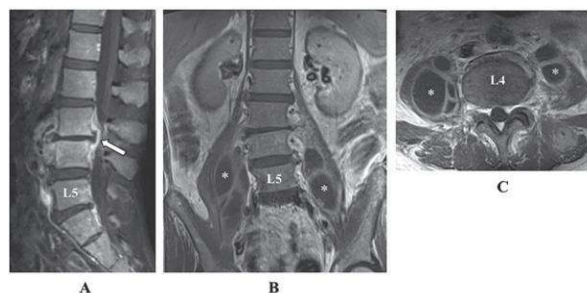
Magnetic resonance imaging (MRI) findings of pyogenic spondylitis in 59-year-old man (same case as Figure 1). The contrast-enhanced T1 weighted sagittal image (A) shows the enhancement of L3-4 epidural abscess (arrow). Coronal (B) and axial (C) contrast-enhanced T1 weighted images show peripheral enhancement of paravertebral abscess (*)¹⁴
